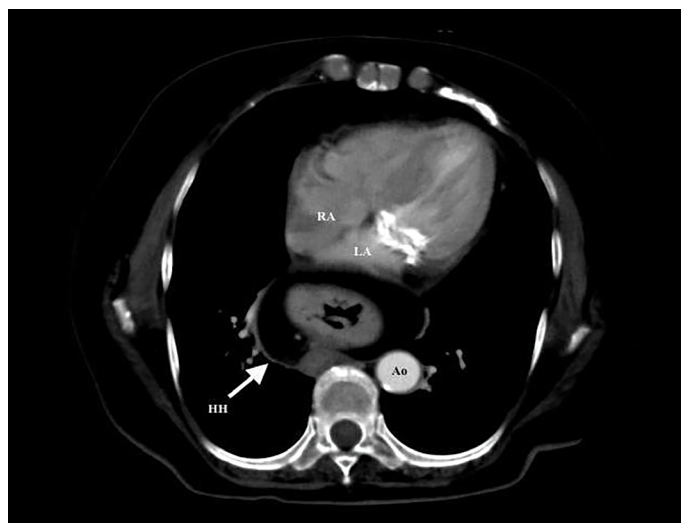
Axial view of thorax computed tomography depicting hiatal hernia posterior to the left atrium
